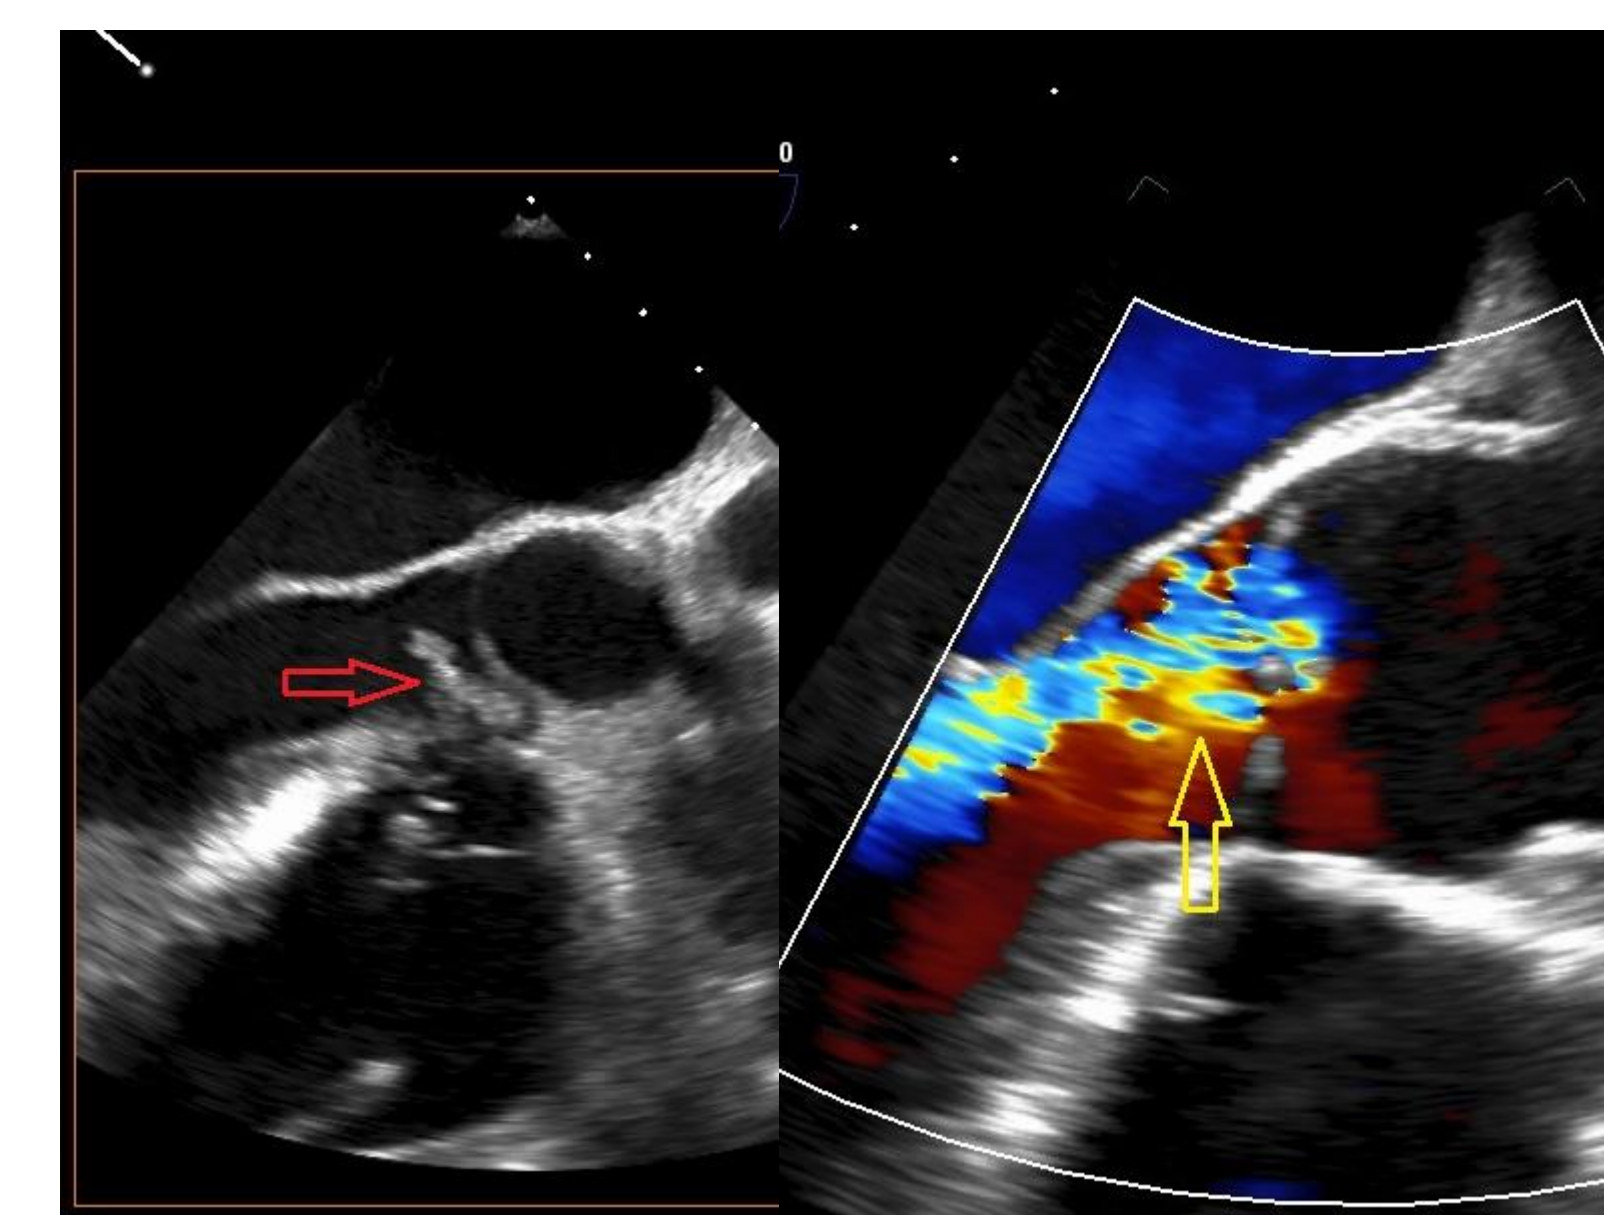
Transoesophageal echocardiogram (aortic valve) demonstrates an independently mobile mass (red arrow) attached to the LVOT aspect of the non-coronary cusp leaflet tip (20 x 5 mm). This was associated with moderately-severe aortic regurgitation at the commissure between the right and non-coronary cusps (yellow arrow).
